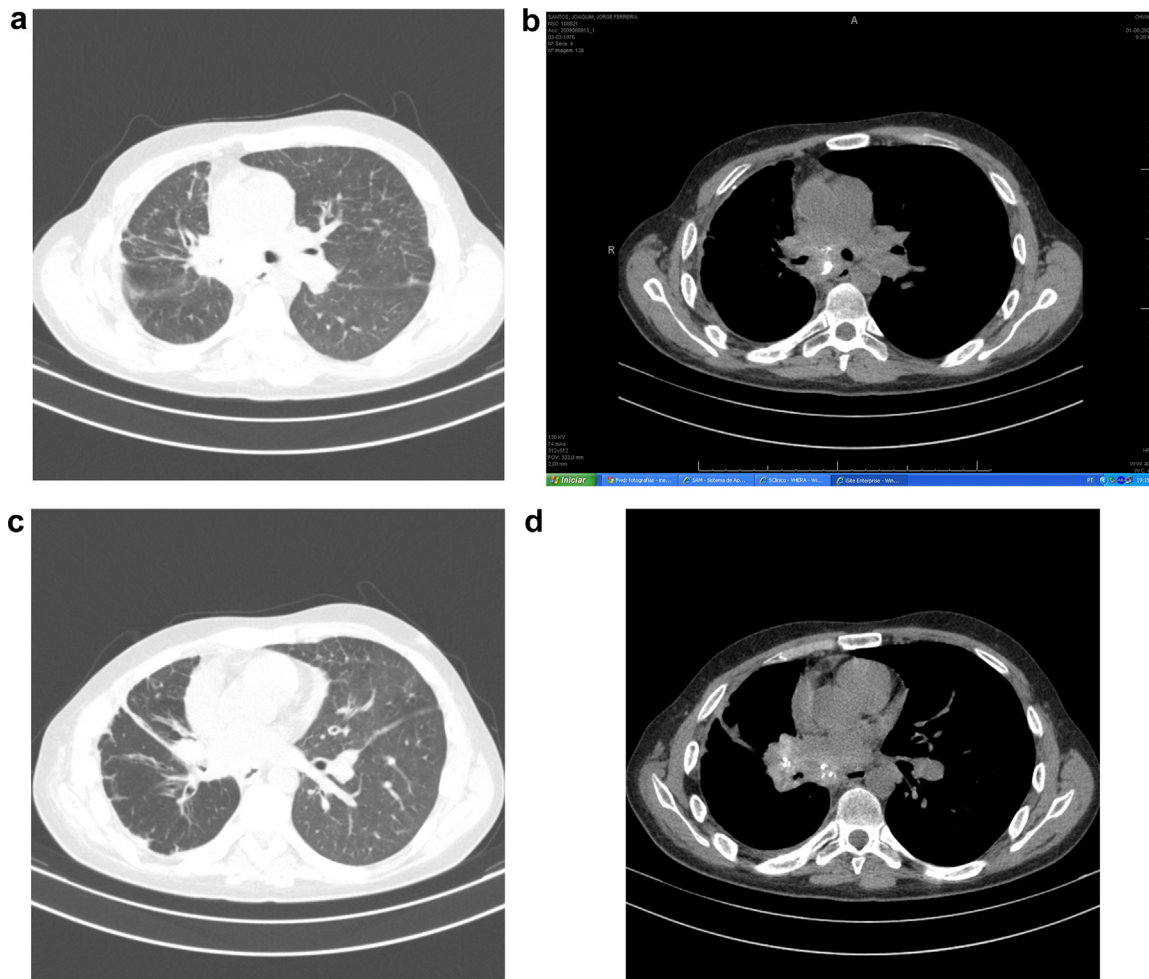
a,b,c: Chest CT with mediastinal mass on right hilar region with right main bronchus caliber reduction, d: Right main bronchus caliber reduction and right pleural thickening.
